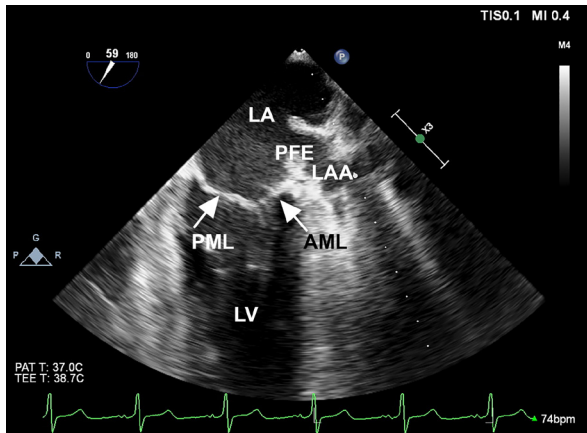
Transesophageal echocardiogram shows a papillary fibroelastoma (PFE) attached to the left atrial (LA) free wall between the LA appendage (LAA) and the anterior mitral valve annulus.
